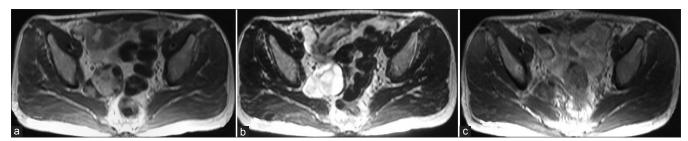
T1-(a) and T2 (b)-weighted axial magnetic resonance imaging showing an iso-intense tumoral mass in the right pre-sacral area. Cystic components are evident in T2-weighted images. An early post-operative image (c), almost at the same level, is also presented
